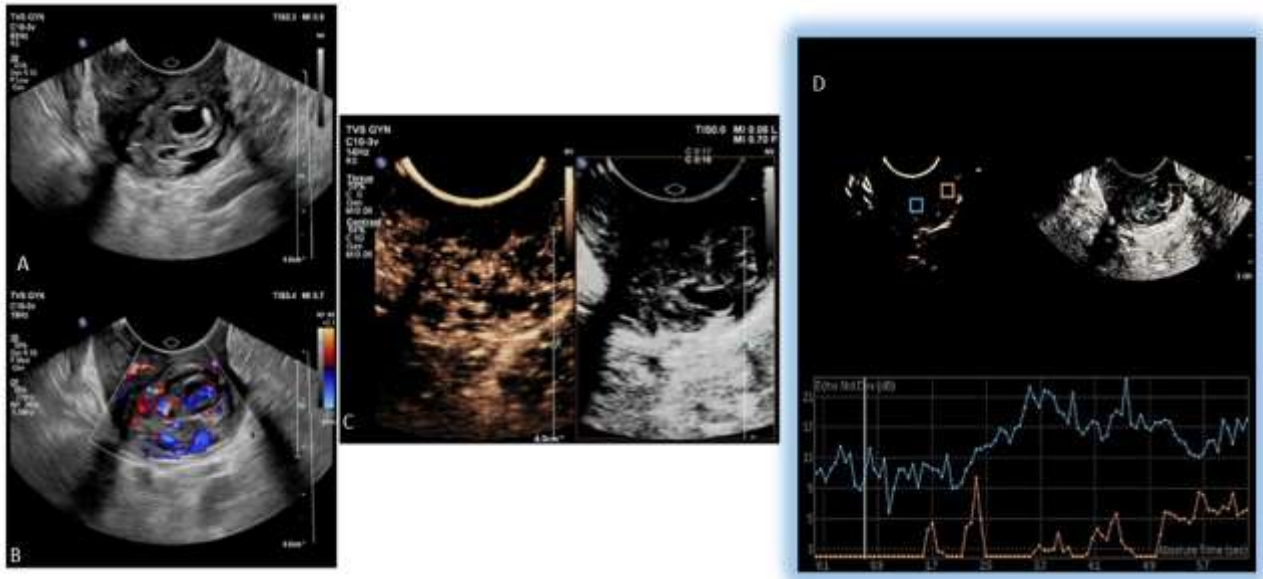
B mode (A) and color doppler (B) images of the vaginal stump lesion showing marked arterial enhancement (C). TIC curves (D) blue ROI in the lesion and red ROI in the normal surrounding parenchyma.
